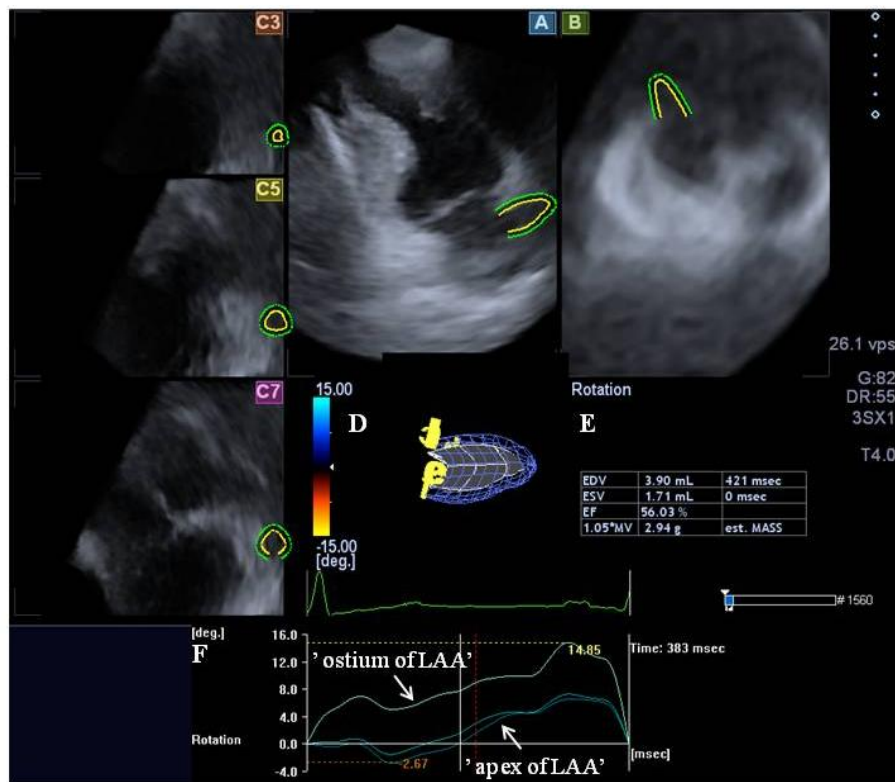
Visualisation of the left atrial appendage (LAA) by three-dimensional speckle-tracking echocardiography. Following optimization of longitudinal sectional planes to the LAA in perpendicular planes (A and B), cross-sectional views were chosen at the ostium of the LAA (C7), at the middle of the LAA (C5) and just before the apex of the LAA (C3). Following manual corrections, a 3D cast of the LAA has also been created (D). Maximum (EDV), minimum (ESV) LAA volumes, ejection fraction and mass of the LAA are also presented (E) together with its rotational characteristics (F).
